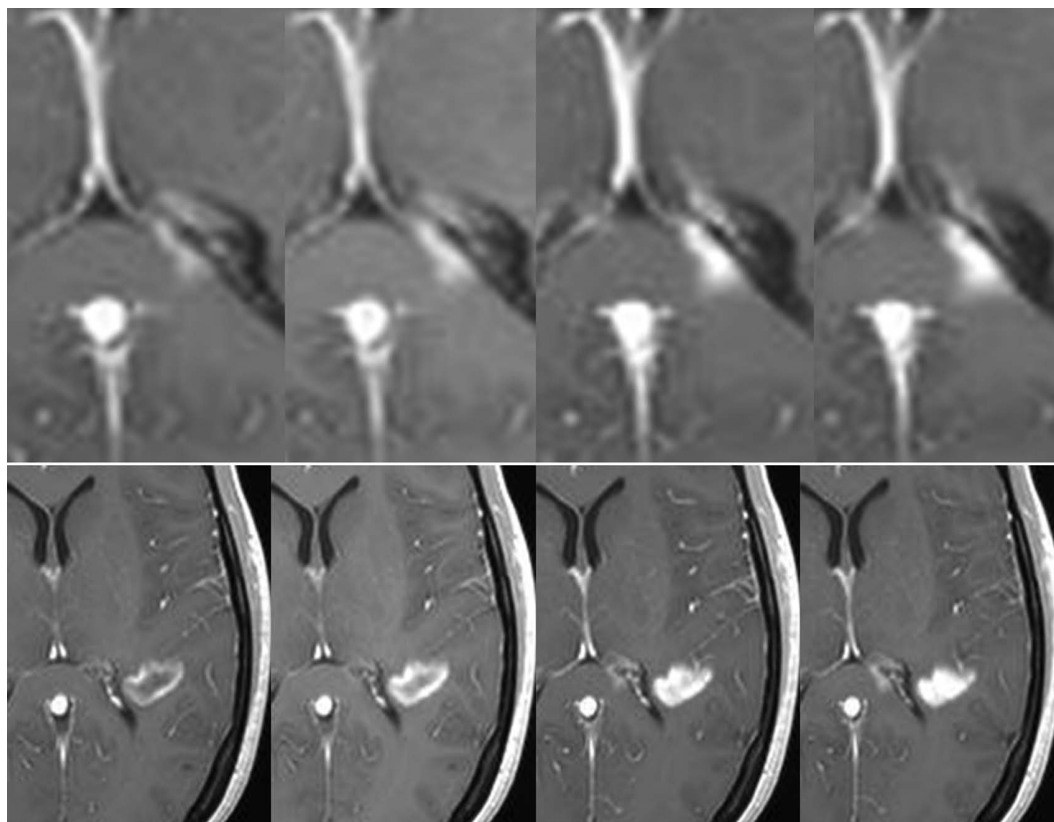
Evolution of contrast uptake in a newly formed lesion. Serial contrast-enhanced T1-weighted images obtained 5, 10, 15, and 20 min after gadolinium injection. A nodular-enhanced lesion located in the splenium of the corpus callosum (upper row) increases in size over time (centrifugal pattern), while an initial ring-enhanced lesion (lower row) becomes nodular (centripetal pattern).
